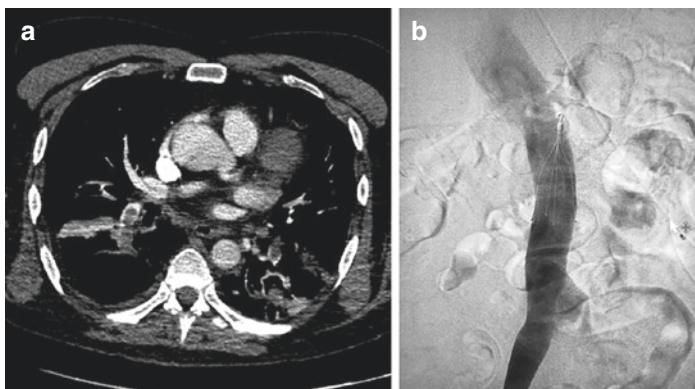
(a) CT with endovenous iodinated contrast agent, arterial phase. Patient with SARS-CoV-2 infection with pulmonary bilateral thromboembolism. (b) Inferior vena cava venogram of percutaneous image-guided insertion of an inferior vena cava filter
